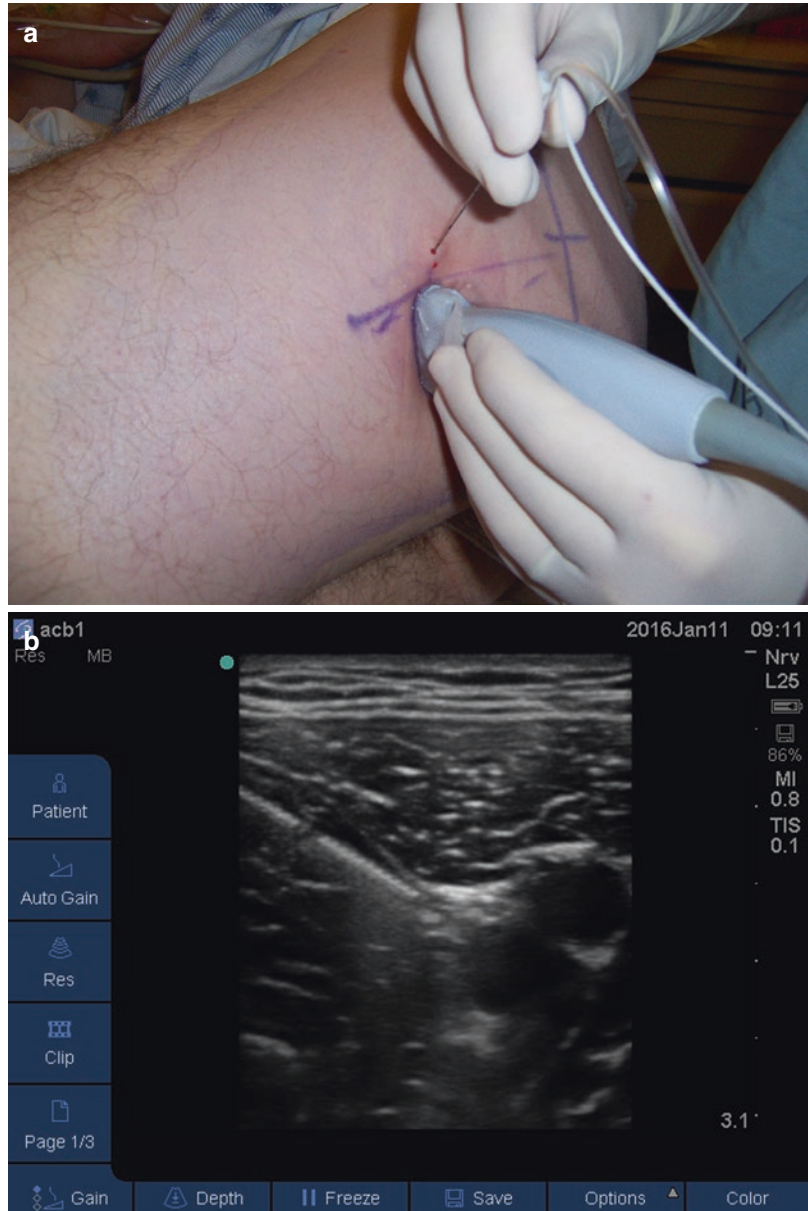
(a) Use of ultrasound guidance to perform femoral nerve block. (b) Ultrasound image of needle adjacent to femoral nerve, before injection of local anesthetic
